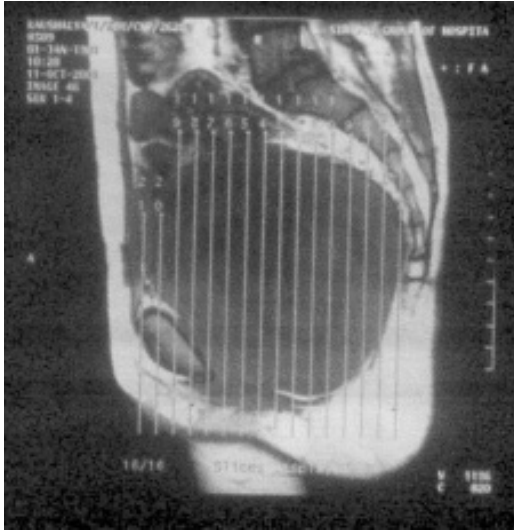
Pelvic MRI (Section).
